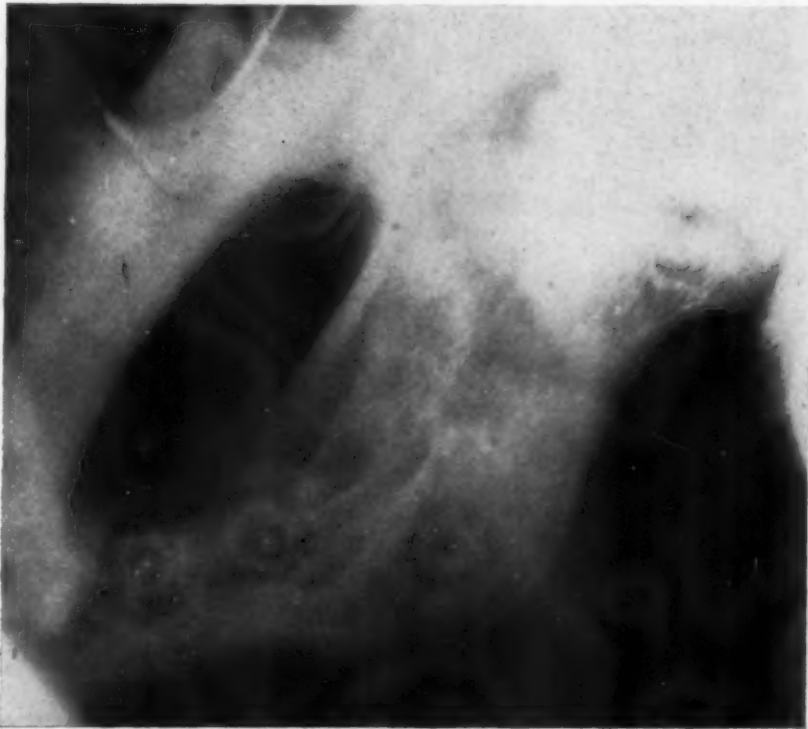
X-ray showing deformed condyle of mandible at the site of ankylosis.
